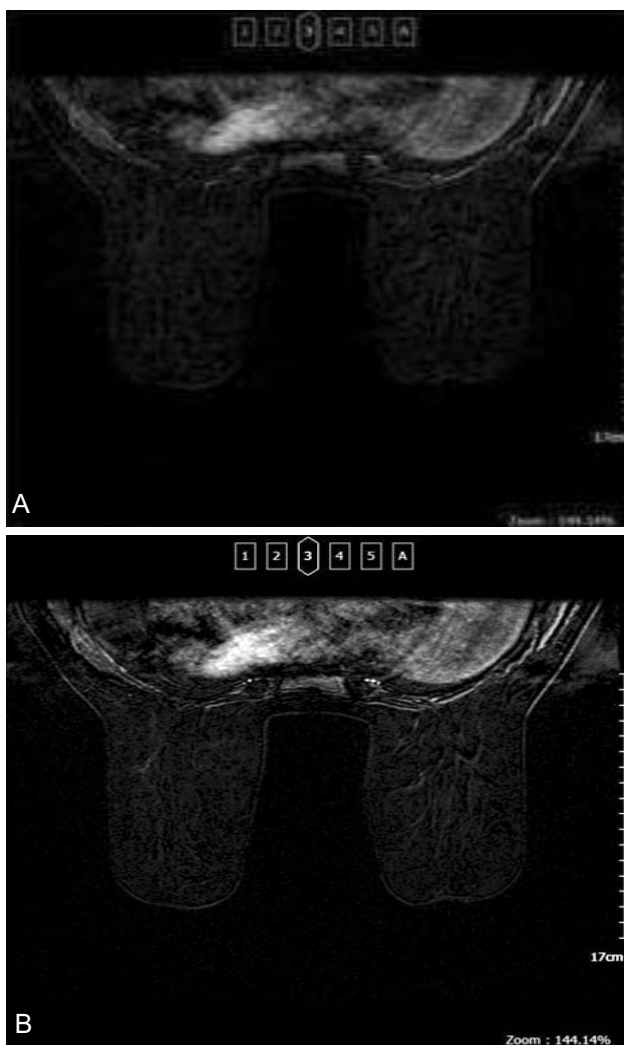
A) Early phase dynamic MRI image and B) Late phase dynamic MRI images after NAC. Both of the left and right breast lesions with total loss of contrast enhancement in addition to the marked decrease in background parenchymal enhancement.
